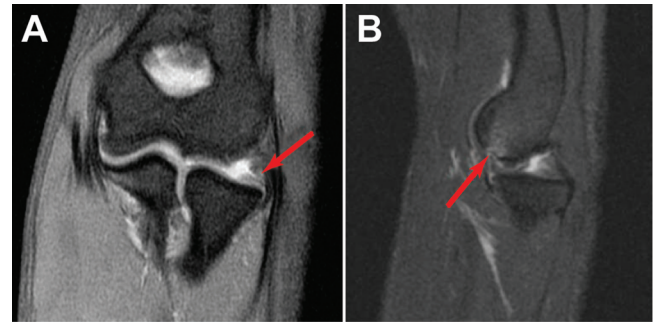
(A) A T2-weighted coronal magnetic resonance imaging scan of the elbow in a patient who had a fall on the elbow while skiing 2 years earlier. The image demonstrates insufficiency of the lateral ulnar collateral ligament (red arrow) and lateral subluxation of the radial head. (B) The sagittal image is notable for posterior subluxation of the radial head and a capitellar chondral defect (red arrow). On physical examination, the patient had evidence of posterolateral rotatory instability and was treated with a ligament reconstruction.
